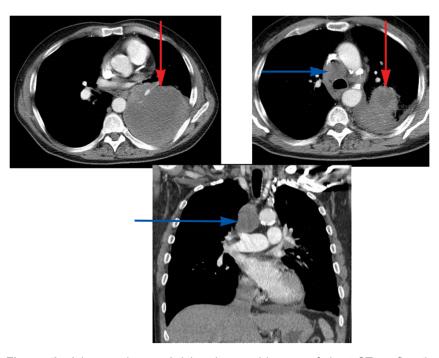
Adenocarcinoma. Axial and coronal images of chest CT confirm the presence of a large mass within the left lung (red arrow). A large necrotic contralateral lymph node was noted (blue arrow). Biopsy proved the mass to be adenocarcinoma. This patient has Stage T3 N3 disease by chest CT criteria. Image courtesy of the University of Massachusetts Medical School, Department of Radiology.
